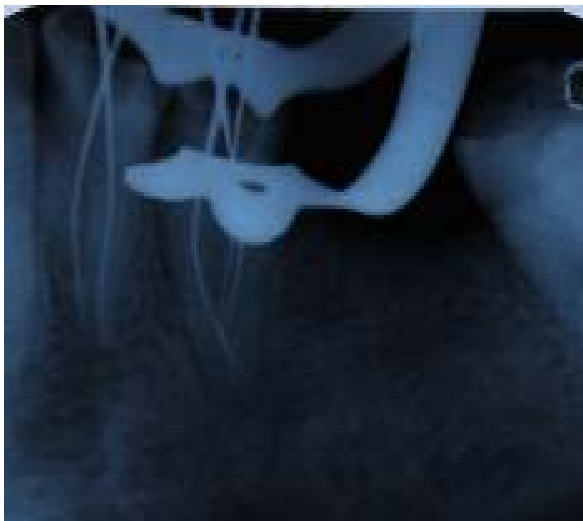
working length x-ray
